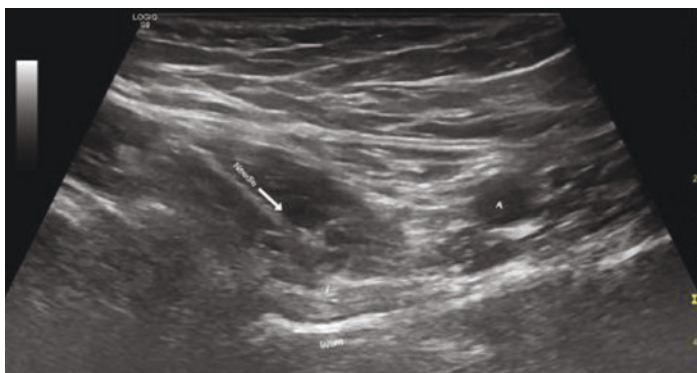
Diagnostic iliopsoas bursa injection under ultrasound guidance. I = iliopsoas tendon; A = femoral artery
